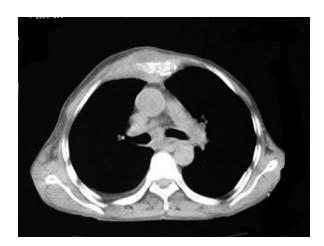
Computed tomography (CT) scan showing destruction of the sternum resulting in a prominent swelling in front of the chest
